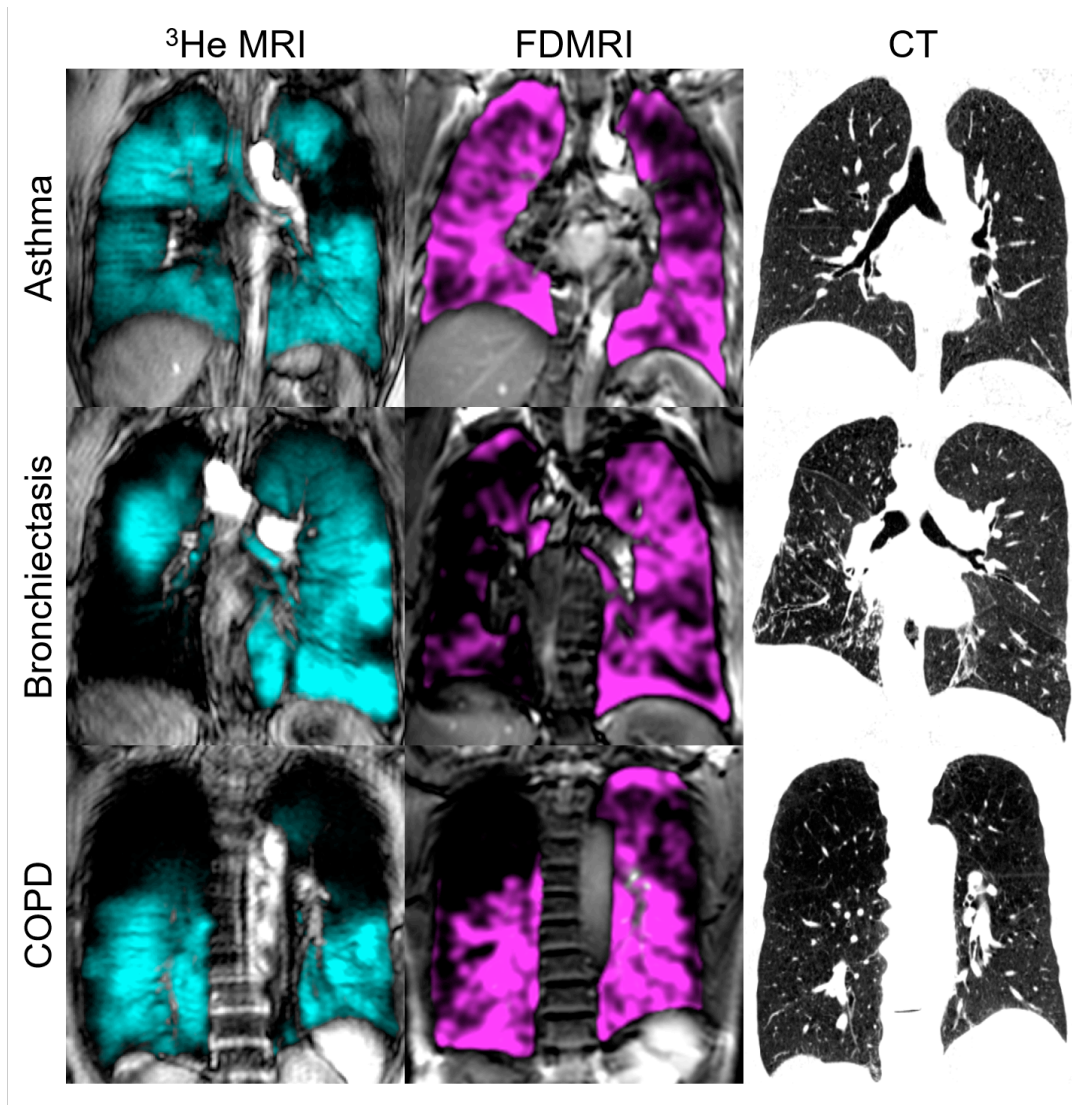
Ventilation MRI and CT of Obstructive Lung Disease
